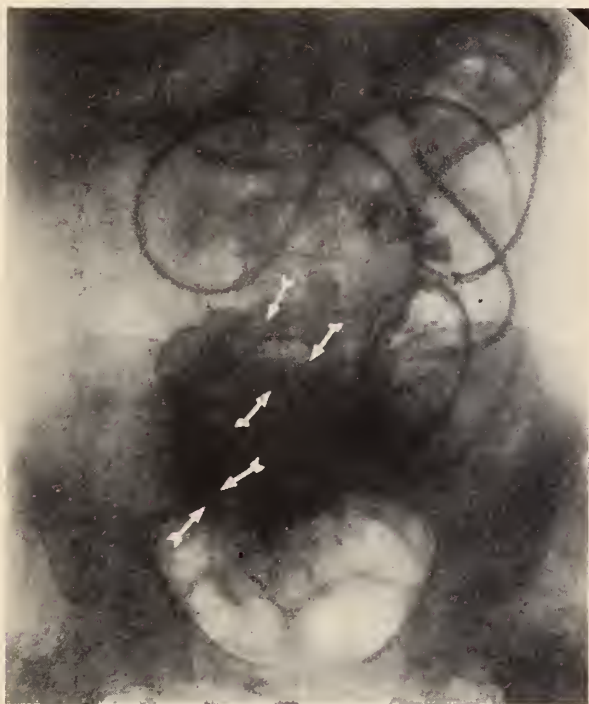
Roentgenogram taken with barium introduced through Miller Abbott tube. Arrows point to stenotic areas in ileum.
